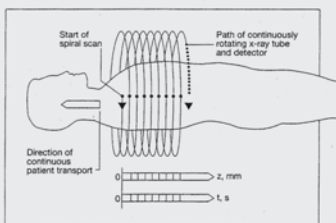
Sketch of the scanning geometry in spiral volumetric CT. t, s = time in seconds, z = section position.
